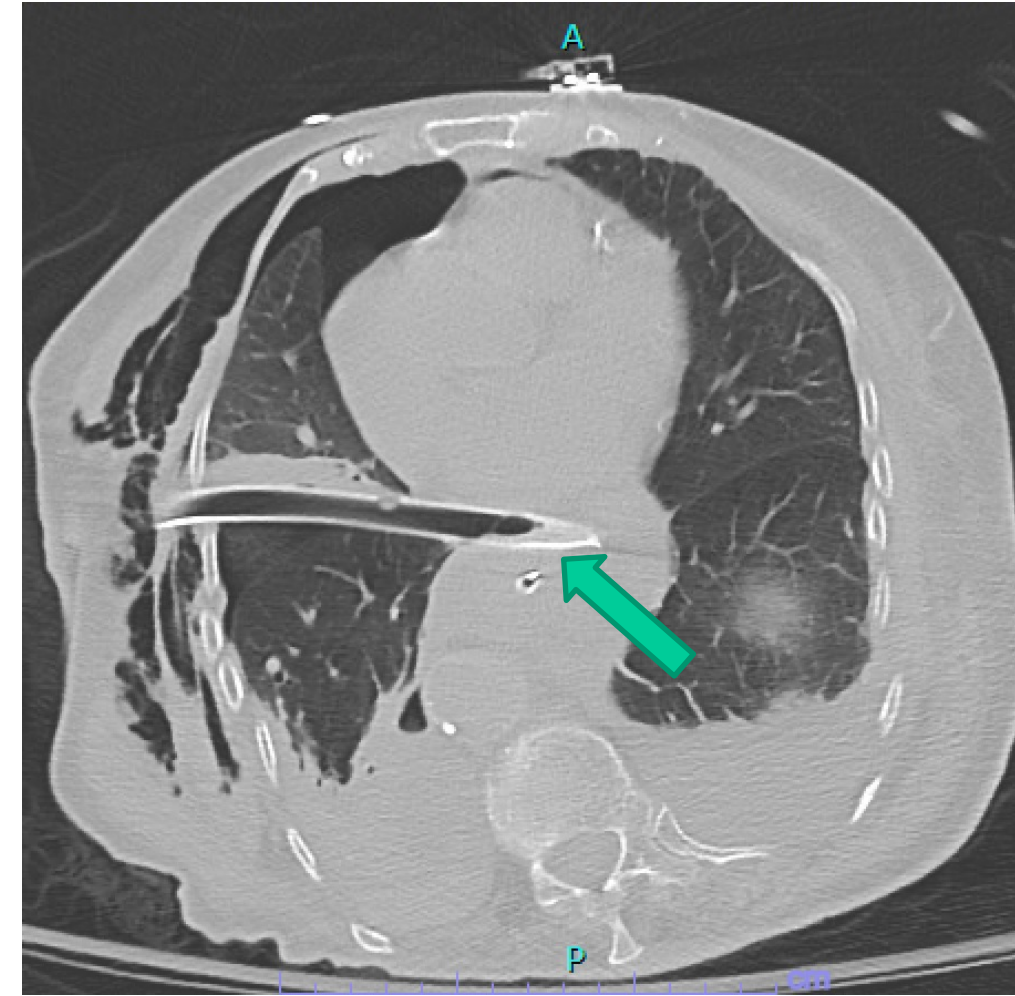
CT scan revealing the right thoracostomy tube traveling through the right middle lobe parenchyma and terminating within the mediastinum between the left atrium and the distal esophagus associated with a right pneumothorax, pneumomediastinum, pneumopericardium and bilateral pleural effusions with a right hemothorax.
